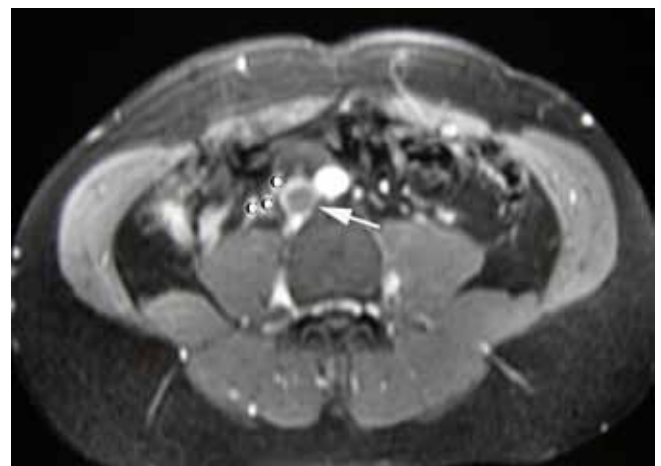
T2-weighted axial MRI comparable in position and image acquisition to Figure 1a demonstrating complete resolution of haematoma and IVC (White Arrow) without thrombus after 4-months of oral anticoagulation therapy.
